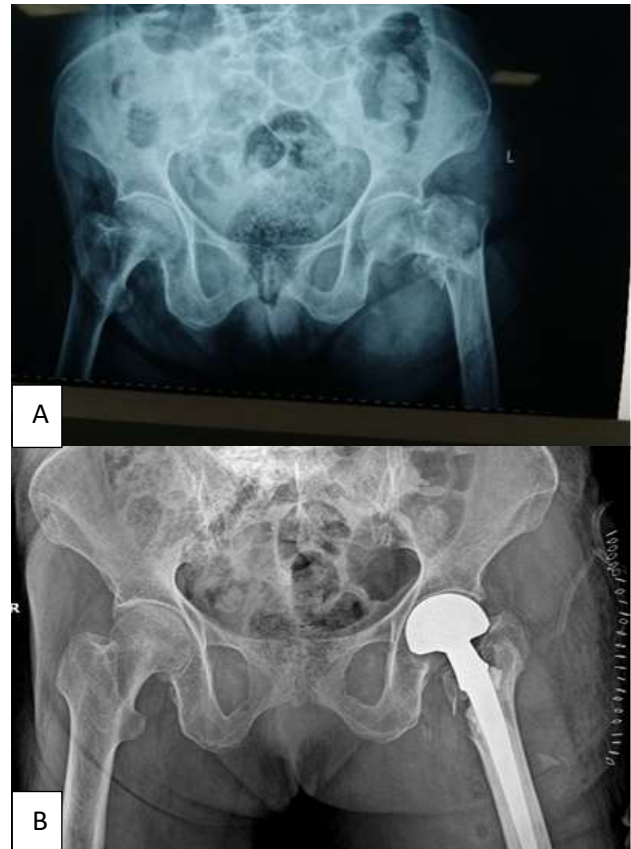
(A and B): Pre-operative and post-operative radiographs of cemented bipolar prosthesis with trochanter fracture fixed with fibre wires.
